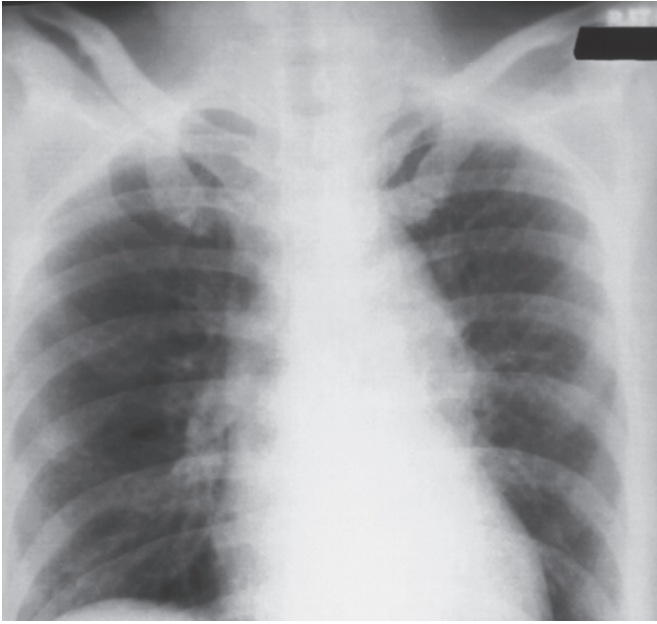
Chest radiograph in a patient with aortic dissection shows widening of the superior mediastinum.
